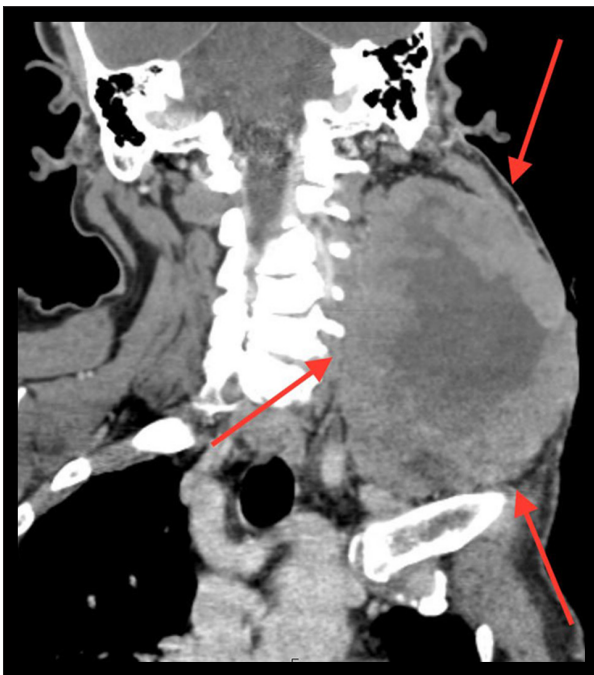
Computed tomography image demonstrating progression with chemotherapy. Arrows denoting tumor borders.
